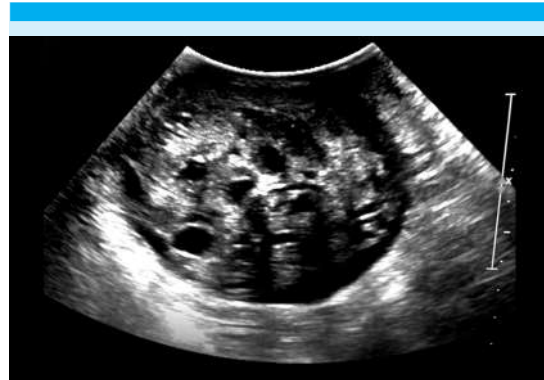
Testicular ultrasound showing a heterogeneous parenchyma with a cystic predominance suggestive of a non-seminomatous germ cell tumor.
